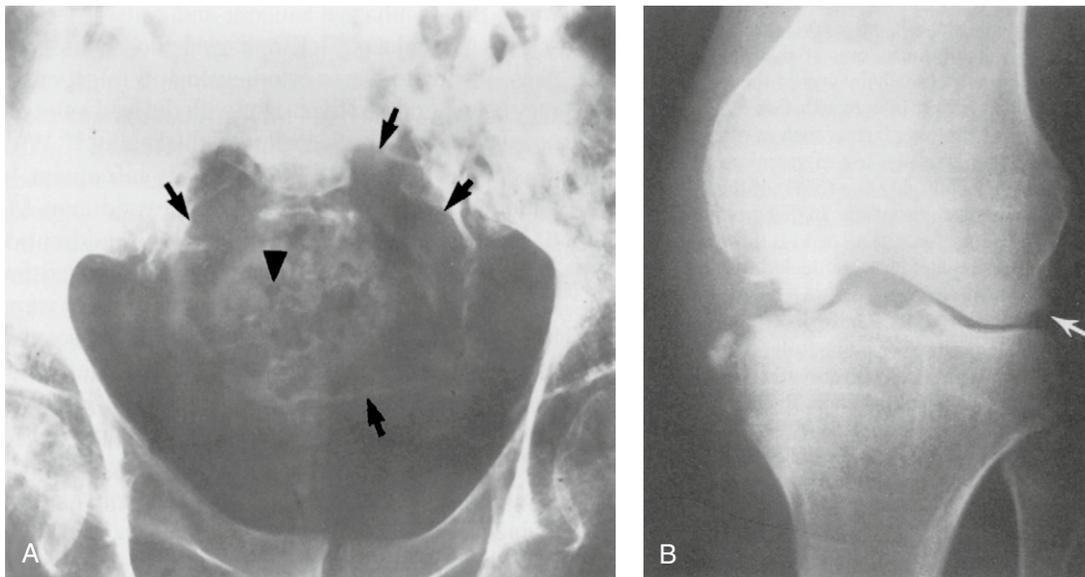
(A) Extensive osteolysis (bone destruction) in blastomycosis. An AP radiograph of the pelvis in an elderly man shows complete destruction of the sacrum, leaving only a thin rim of bone (arrows). There is superimposition of rectal stool (arrowhead). Osteolysis is seen in flat bones involved with *Blastomyces* osteomyelitis. (Case courtesy of Dr Rebecca Loreda, San Antonio, TX.) (B) Septic arthritis due to *Candida*. There is joint space narrowing with marginal erosions (white arrow). Also note sclerosis and fragmentation of the distal femur and proximal tibia. (Reproduced with permission from Resnik²⁰²).
